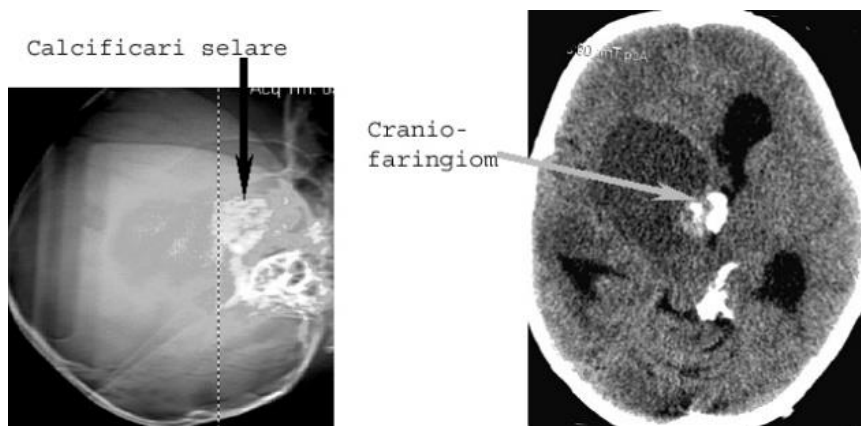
Craniopharyngioma (Radiography and CT – scan)⁵
